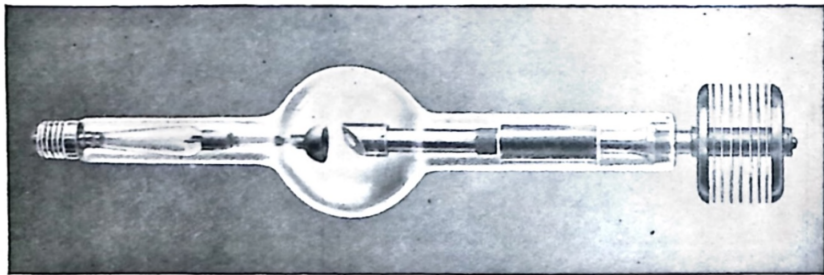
Radiator Type Coolidge X-Ray Tube
